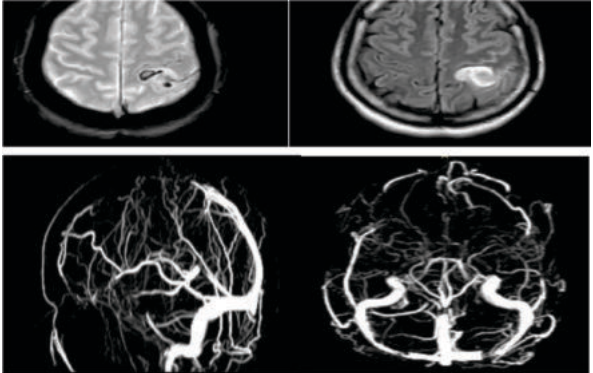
a) Axial GRE sequence showing blooming in left high posterior parietal lobar region. b) Axial FLAIR image showing high signal intensity left high posterior parietal lobar region. c) and d) MR Venogram images showing absent flow related signal intensity noted involving anterior and middle aspect of superior sagittal sinus and adjacent cortical veins.
